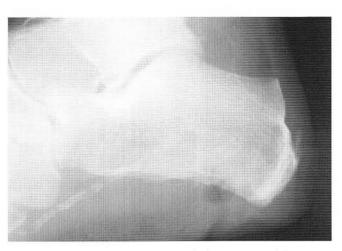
Preoperative lateral radiograph showing cortical destruction of the inferior plantar calcaneal cortex.
